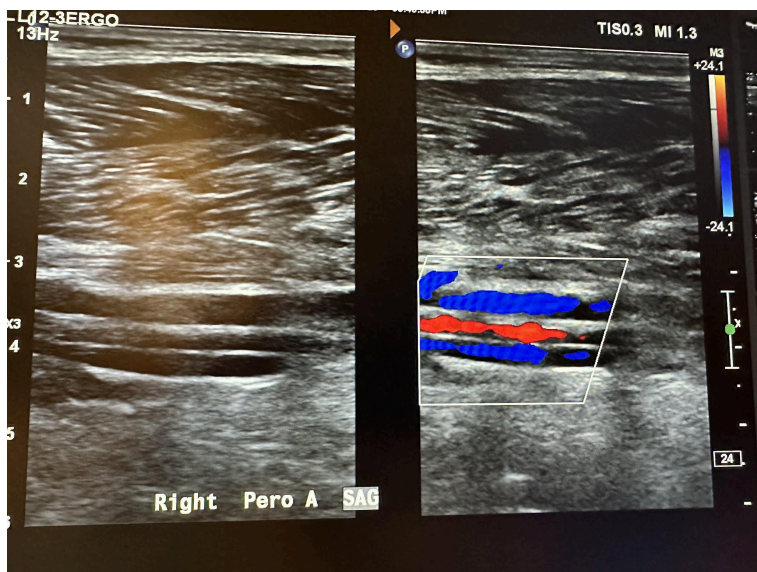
Side-by-side sagittal images of the right peroneal artery without color Doppler and with color Doppler.
